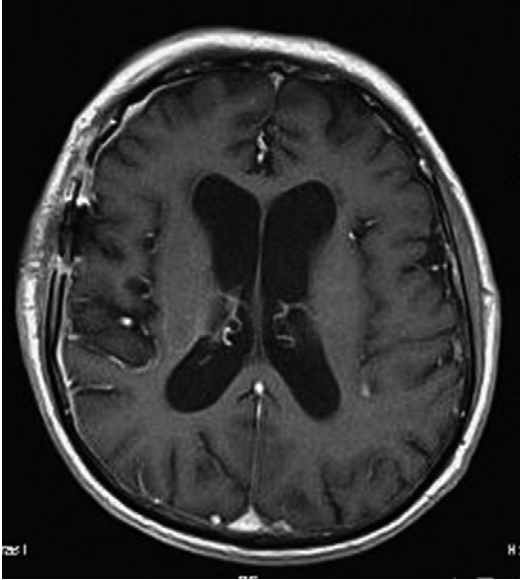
Axial T1-weighted image, post contrast medium administration, shows no foci of abnormal contrast enhancement in the periventricular area of the right brain hemisphere. No evidence of residual disease is identified
